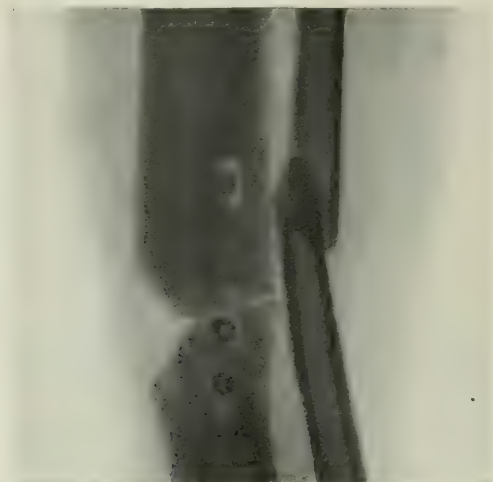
Roentgenogram showing transverse fracture of tibia and fibula, Case 7.
